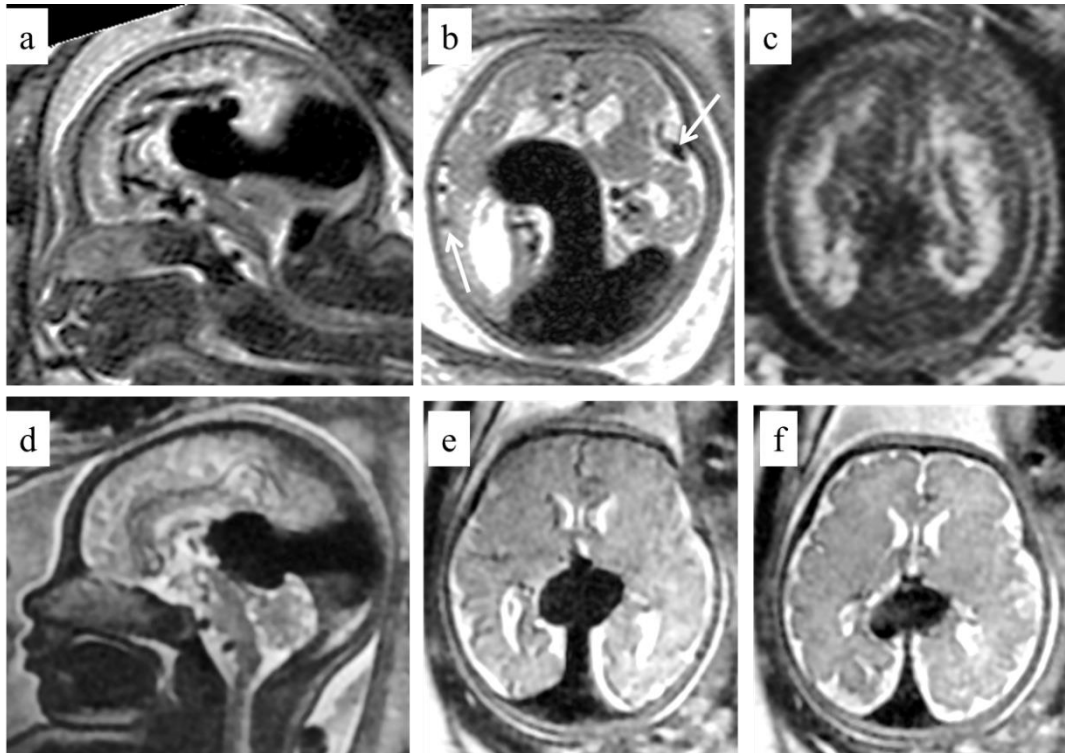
Two fetuses with vein of Galen aneurysmal malformations. The first fetus (6a-6c) imaged at x gw (ESS) shows a large vein of Galen aneurysmal malformation with extensive loss of volume from the cerebral hemispheres on sagittal (6a) and axial (6b) T2-weighted images and abnormal high signal on T1-weighted images (6c), probably indicating micro-hemorrhage or micro-calcification. Comparison is made with another fetus with a vein of Galen aneurysmal malformation imaged at 34gw in which there is no loss of volume or encephalomalacia (6d-6f). Note the enlarged branches of the middle cerebral artery in the fetus with encephalomalacia (arrowed on 6b) described as the 'pseudofeeder' sign resulting from impaired cerebral blood flow that are not present in the other fetus - see the text for details.
